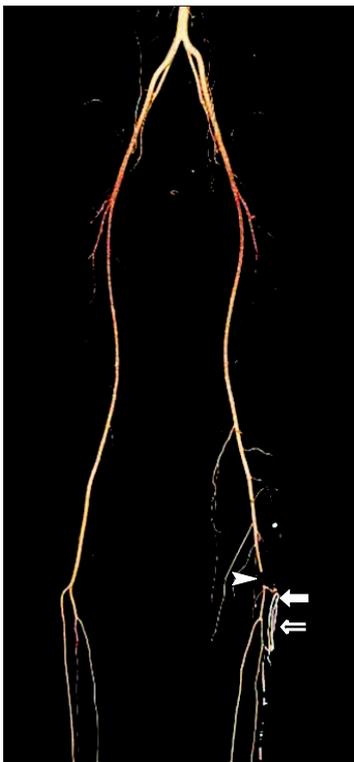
The computed tomography angiogram shows filling defects along the entire course of the anterior tibial artery (arrow), a section of the popliteal artery (arrow head), and collateral vessels around the bicortical screw fixation site (open arrow).
